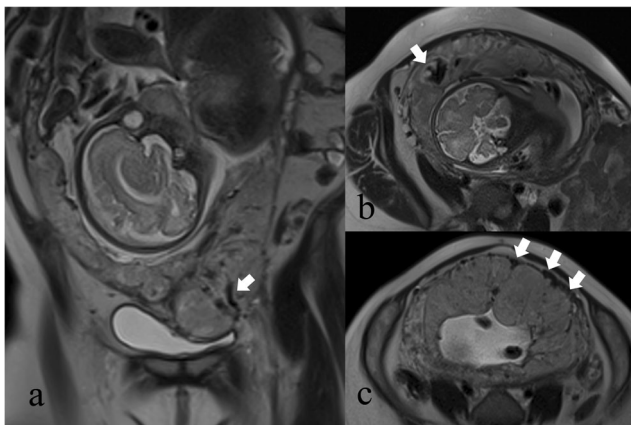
(a) Coronal T2-Haste MR image demonstrates bridging vessels (arrow) through the bulging placenta in a 25-year-old woman at 32 weeks' gestation with placenta percreta (PP). (b) Axial T2-Haste MR image demonstrates abnormal intraplacental vascularity (arrow) in a 28-year-old woman at 30 weeks' gestation with placenta increta (PI). (c) Axial T2-Haste MR image demonstrates uterine serosal hypervascularity (arrows) in a 34-year-old woman at 35 weeks' gestation with PP
